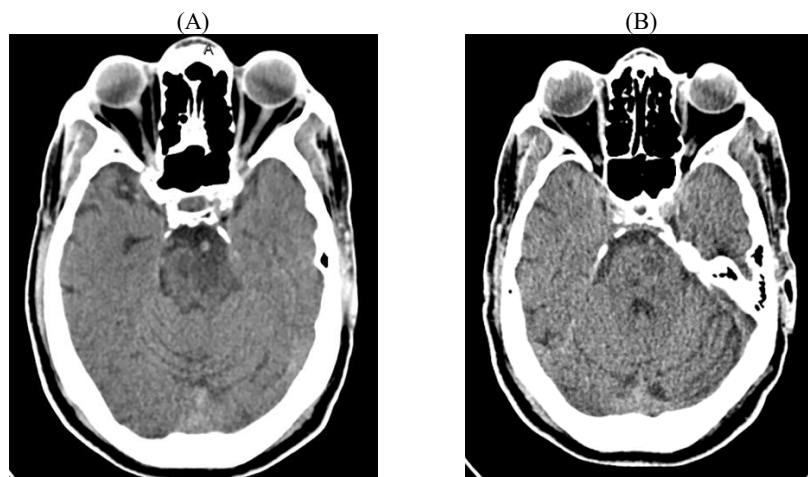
M/74. (A) Midbrain level, (B) Pons level. This patient complained of a sudden attack of the right sided weakness. Non-contrast CT of the transaxial view reveals ischemic brain infarction of the left midbrain and pons junction level.
